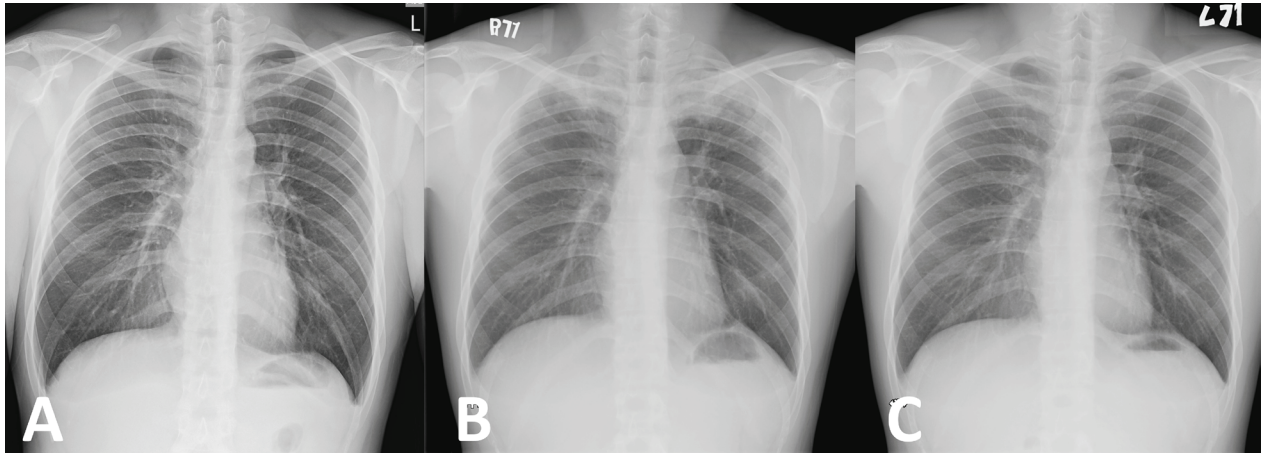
Serial Changes in Chest Radiography.(1A). Chest radiography taken 3 months before presentation showed no active lung lesion.(1B). Chest radiography taken on the day of presentation showed airspace lesions in bilateral apical areas; (1C). Chest radiography taken 10 days after steroid treatment showed marked regression of the apical lesions.
